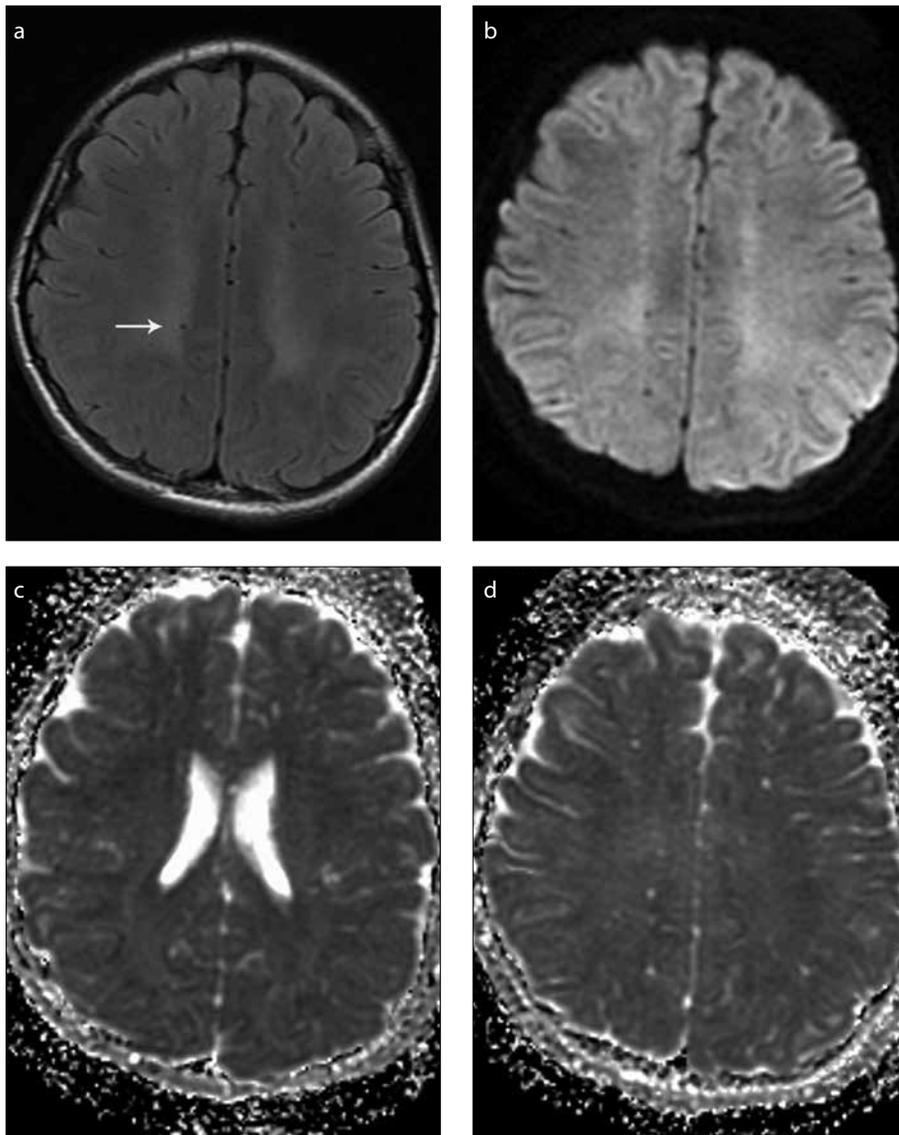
a–d. An 11-year-old female with MSUD (patient 5). Axial T2-FLAIR image (a) shows hyperintensity in the centrum semiovale (arrow). Axial sections of the DWI (b) show bilaterally symmetrical hyperintensity in the centrum semiovale. Axial ADC map (c) does not show any ADC reduction corresponding to FLAIR hyperintensity signal in periventricular areas and axial ADC map (d) does not show any ADC reduction corresponding to the centrum semiovale.
